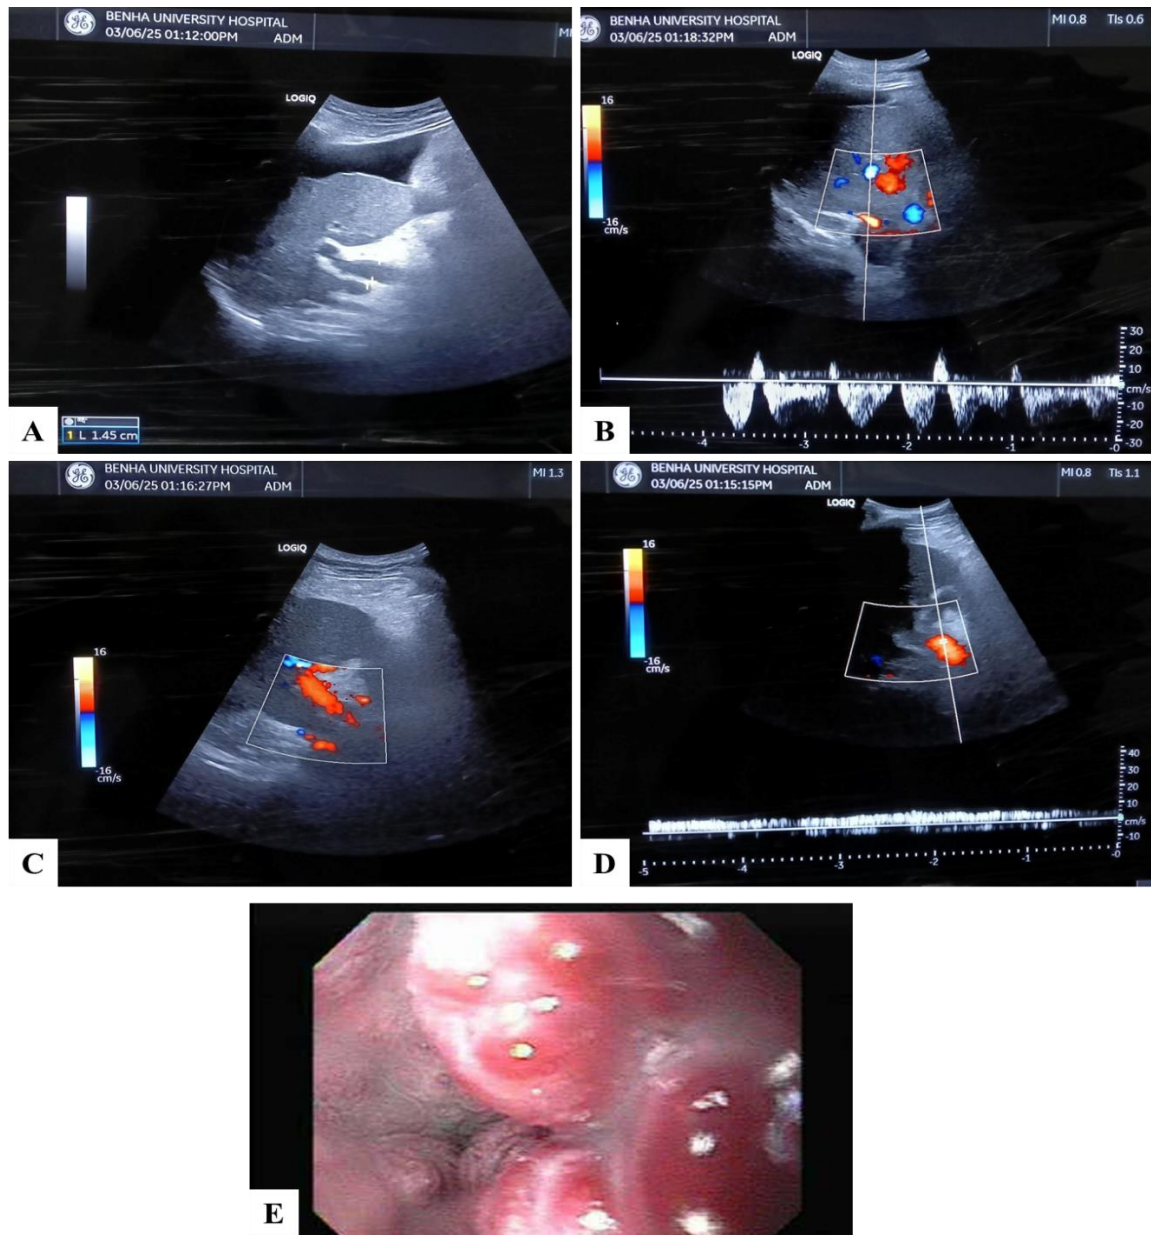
case 1: A 77-year-old male patient, hypertensive, diabetic, and a heavy smoker, with a history of bilharziasis, presented with hematemesis. He had a BMI of 19, hemoglobin of 9.7 g/dL, INR of 2, platelet count of $94 \times 10^9/L$, creatinine of 0.9 mg/dL, and was classified as Child-Pugh class B. A) Cirrhotic liver with ascites & PVD measuring about 14mm. b) Preserved hepatic venous Doppler (triphasic wave pattern). C) Normal hepatopetal color Doppler of PV. D) PV wave pattern with PVFV=8.1cm/sec. E) Upper GI Endoscopy Findings: Three cords esophageal varices (OV) grade III, risky. Agreement between DUS and Upper GI Endoscopy finding = low PVFV consistent with presence of OV, but triphasic hepatic venous wave pattern neither consistent with the presence nor the high grade of OV.
